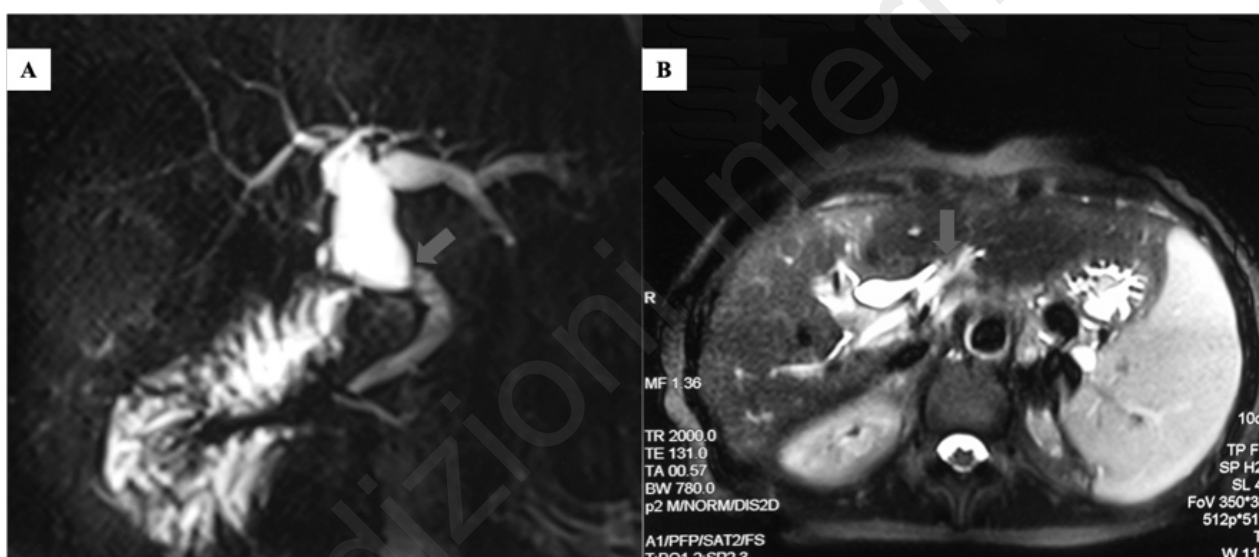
Imaging findings of common bile duct anastomotic stenosis. A) Cholangiography; B) Computed tomography.
